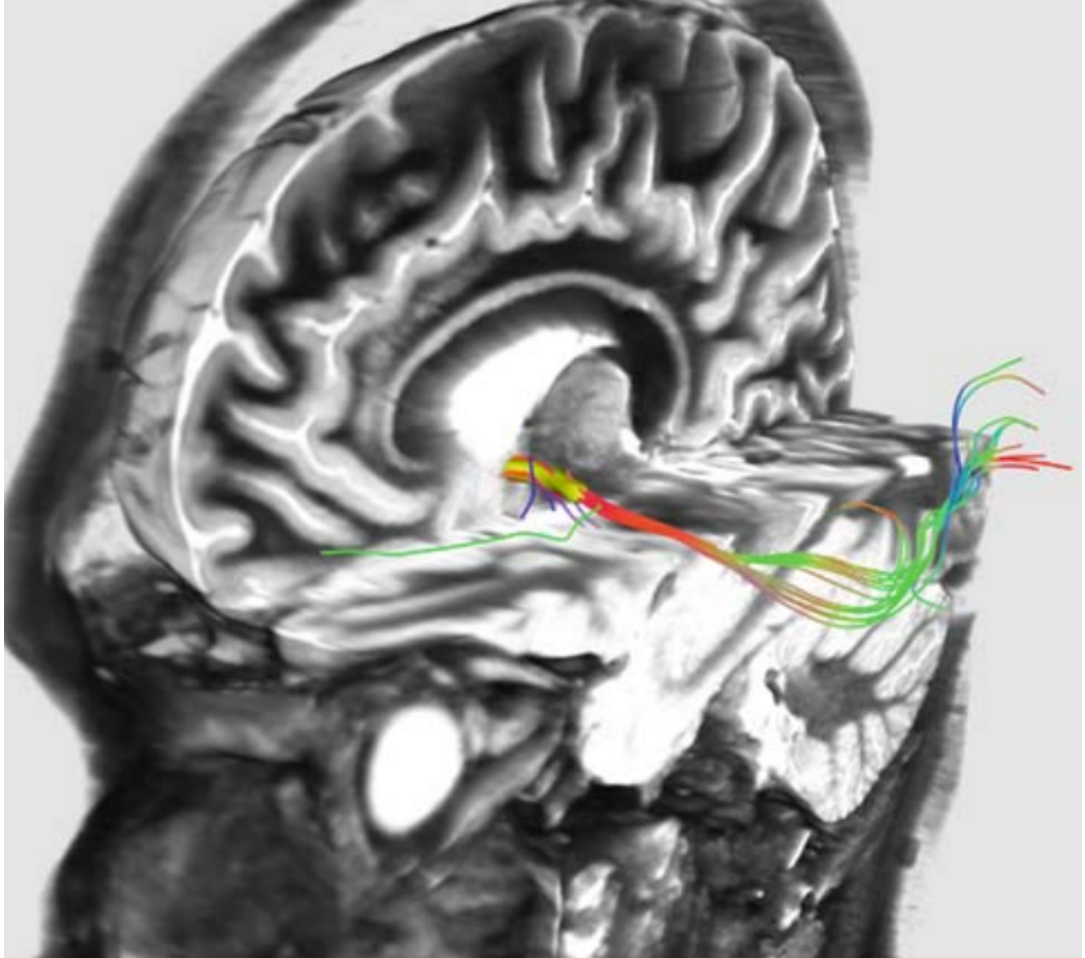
Image showing the anterior commissure fibres from a single subject projected onto the three-dimensional T2-weighted volume, for assessing distribution of the tracts
